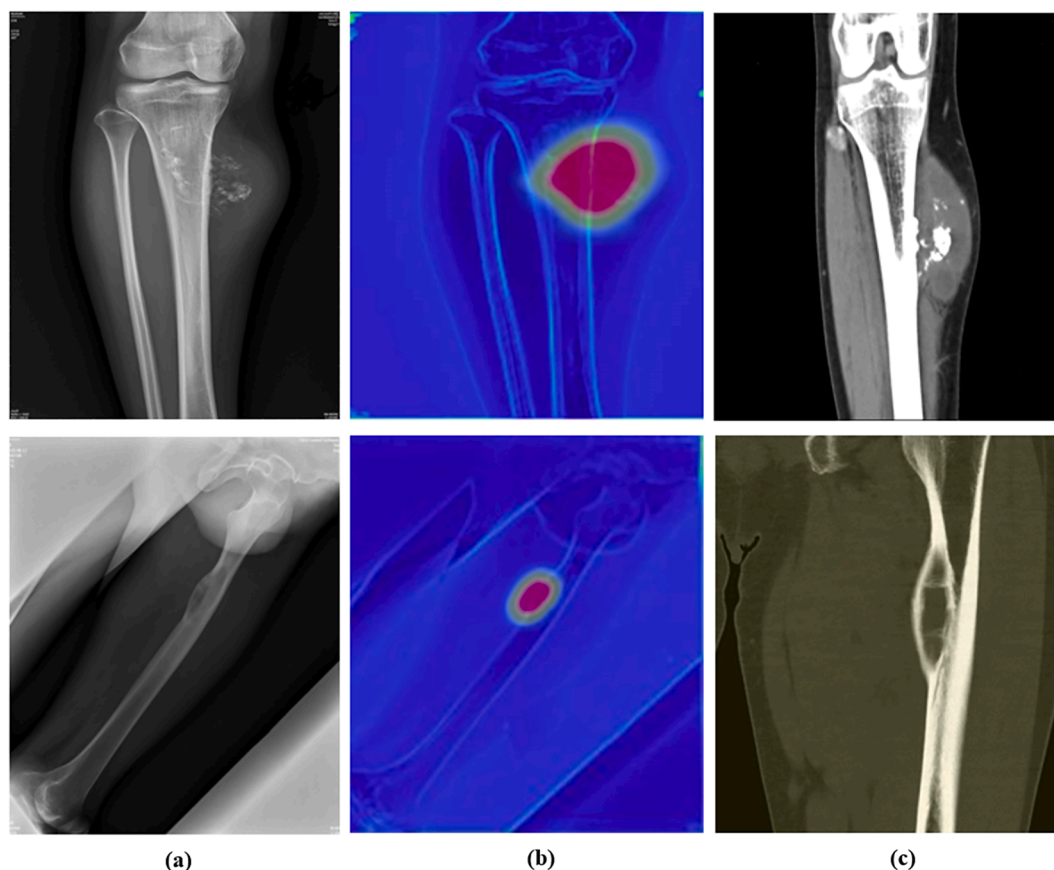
Grad-CAM showed the position of a tumor. Whereby (a) is original image by radiography, (b) is the position of a tumor highlighted by Grad-Cam, and (c) is the final verified CT image for the position of a tumor.
